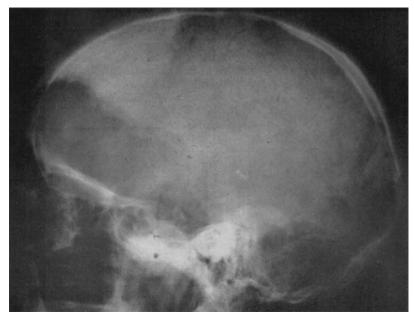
Lateral radiograph (reduced) of the same skull as in fig. 1, showing in the tangential view the finely stencilled outlines of the inner and outer tables.
